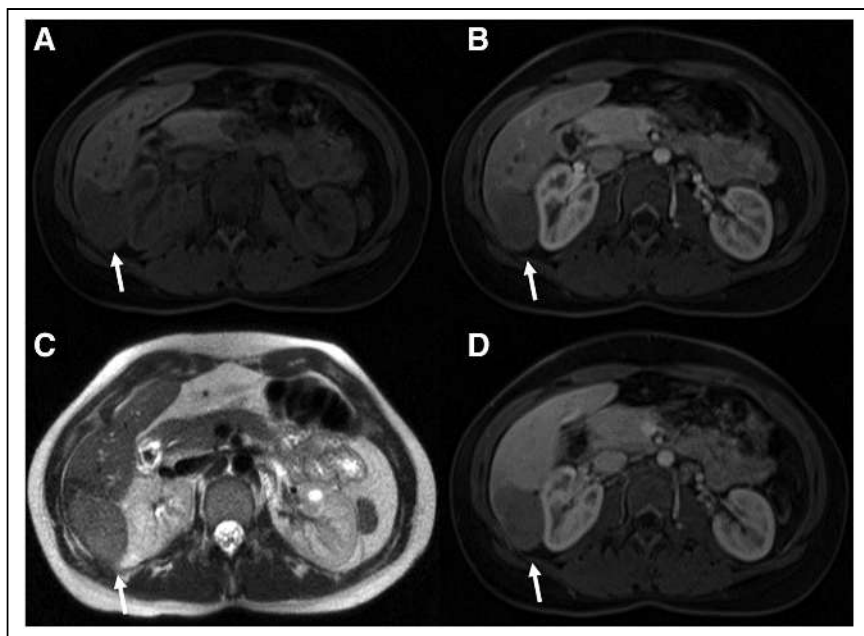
Axial MR images of area of lesion (arrows). (A) T1-weighted fat-saturated volumetric interpolated breath-hold examination (VIBE) sequence shows typical hypointensity. (B) Arterial-phase T1-weighted VIBE sequence shows no uptake of gadopentetate disodium (Eovist; Bayer). (C) T2-weighted sequence shows typical hyperintensity. (D) Portal venous-phase T1-weighted VIBE sequence shows no gadopentetate disodium uptake.
